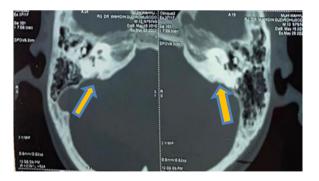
Temporal Bone CT Scan
